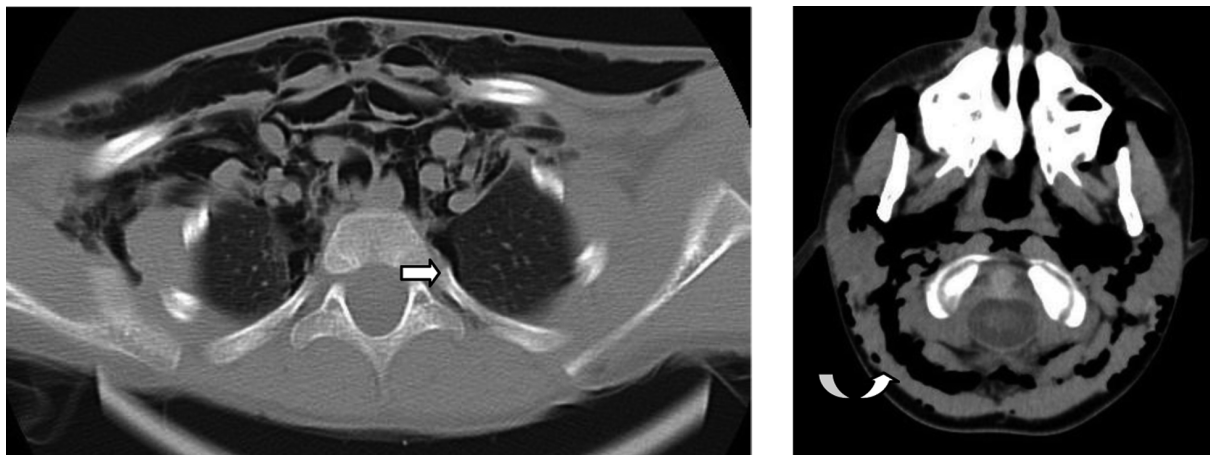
Lung CT scan (arrows)
